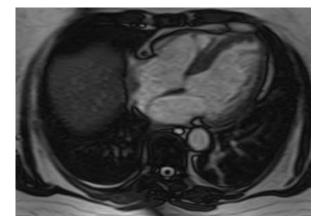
Cardiac MRI four-chamber view (bright blood) with no evidence of LV soft tissue mass.
